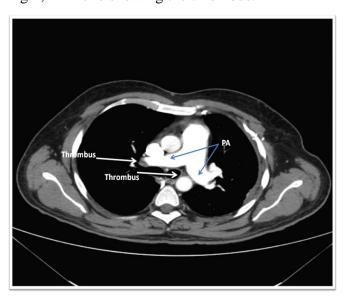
CT pulmonary angiography showing partially obstructive filling defect in left pulmonary artery.
